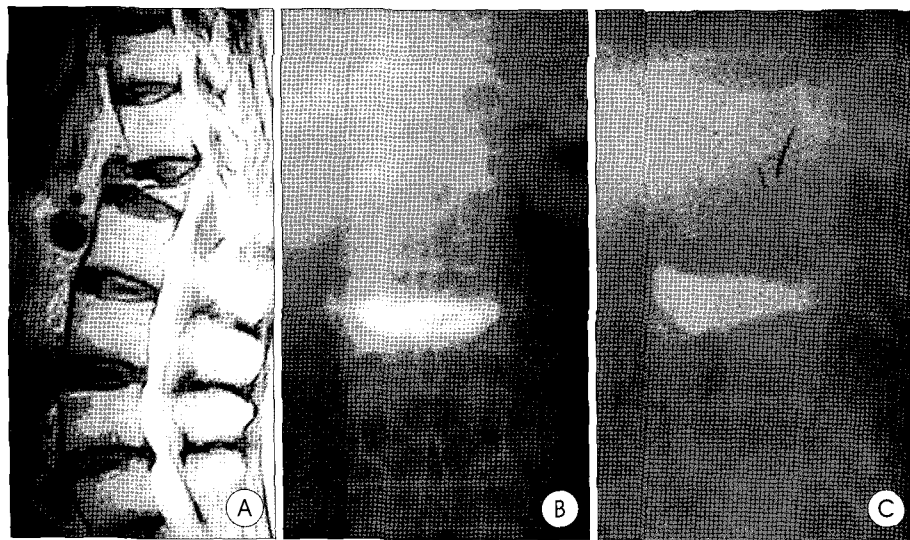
Images in a 82-year-old woman with vertebra plana for severe compression of L1 vertebral body. A : Sagittal T2 weighted MR image shows severe compression fracture of L1 and increased signal intensity due to fluid and edema (about 15% of original height). B, C : Simple X-rays obtained after methylmethacrylate injection show complete filling of L1 vertebral body without any leakage.
